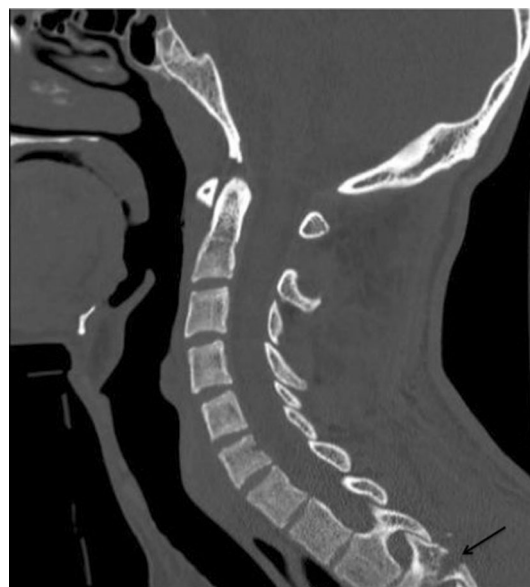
Sagittal cervical CT scan showing compensatory hyperlordosis above the fracture site (black arrow)
